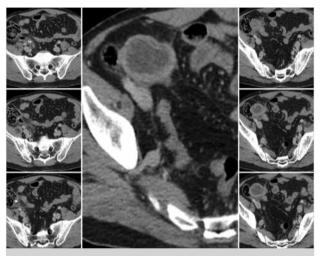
CT sections in which proximal and distal intraluminal hyperdense lesions that suggests acute appendicitis and cystic mass in the right lower quadrant are viewed together
